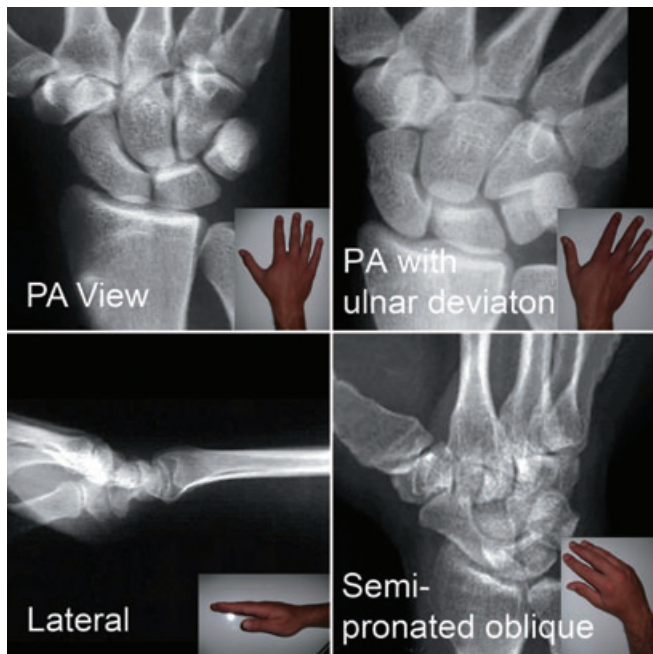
Standard recommended scaphoid x-ray views. Postero-anterior (PA), PA with ulna deviation, lateral and semi-pronated oblique views. Position of hand and wrist relative to x-ray tubing shown with insert showing the x-ray taken.
